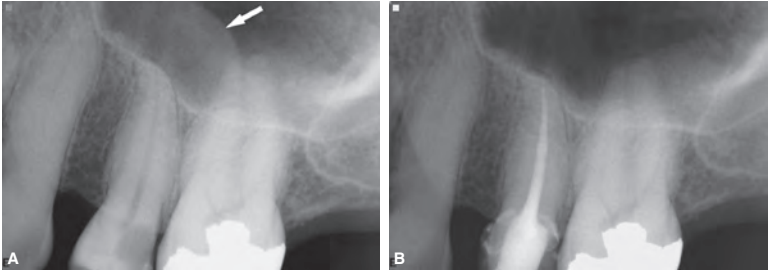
Periapical mucositis. A, Radiograph of a mucositis lesion, shown as a “dome” in the left maxillary sinus apical to tooth #13 (arrow). B, Follow-up radiograph taken 6 weeks after root canal treatment showing full resolution of the mucositis.
